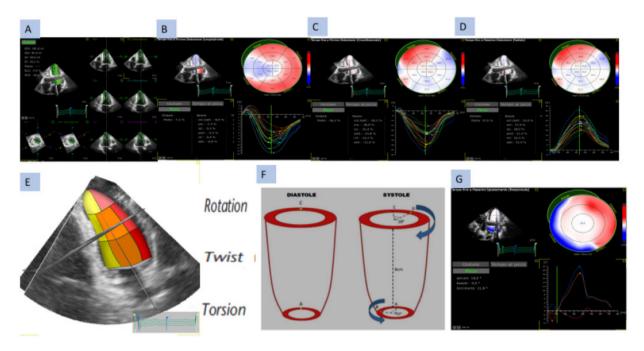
Three-dimensional speckle tracking transthoracic echocardiography. Measurement of longitudinal, circumferential, radial strain (A-D), and rotational mechanic indices (rotation, twist, and torsion) (E-G).
